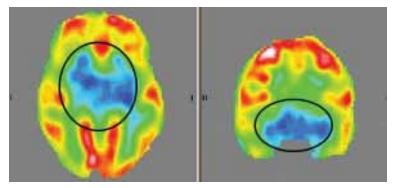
PET CT scan of the brain in autism. The areas of reduced metabolism and FDG uptake are seen in different shades of blue colour.
